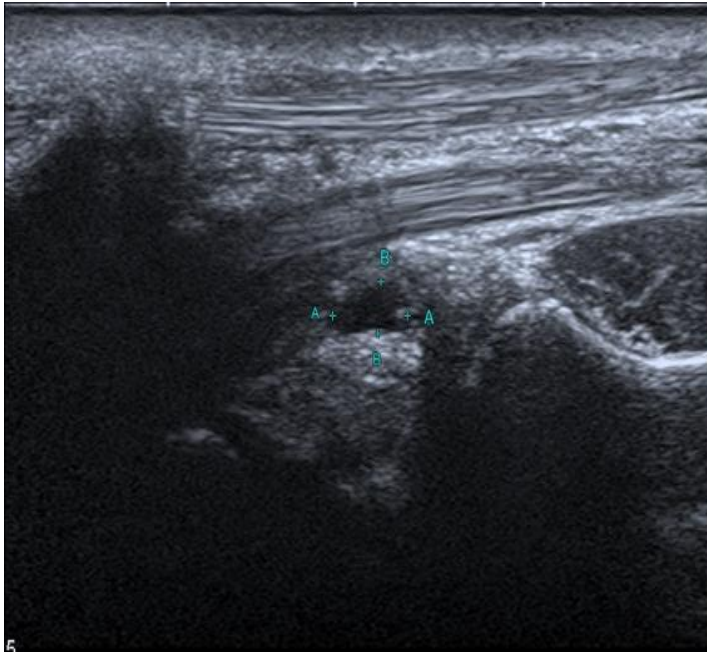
and 4): A 22 years old male patient complaining from ulnar sided wrist pain and tenderness. History of trauma 14 years ago with no osseous related cause. Figure 3 shows ultrasound images that shows Ganglion cyst deeper to flexor digitorum tendons, it measured 4x2mm Figure 4 Normal MRI.
